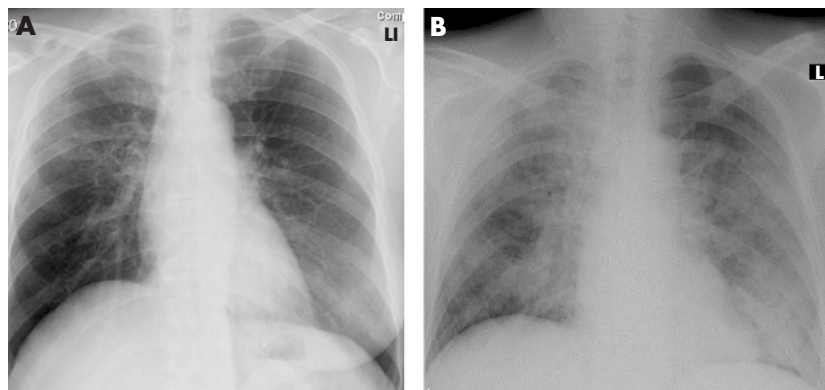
Chest radiograph: (A) taken 1 day earlier; (B) with evidence of bilateral alveolar filling.
